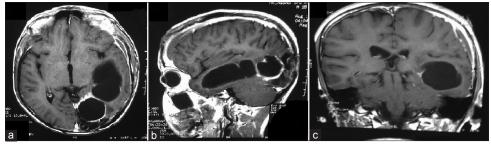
(a-c)TI-contrast enhanced MRI head performed 6 months postoperatively suggestive of recurrent disease
